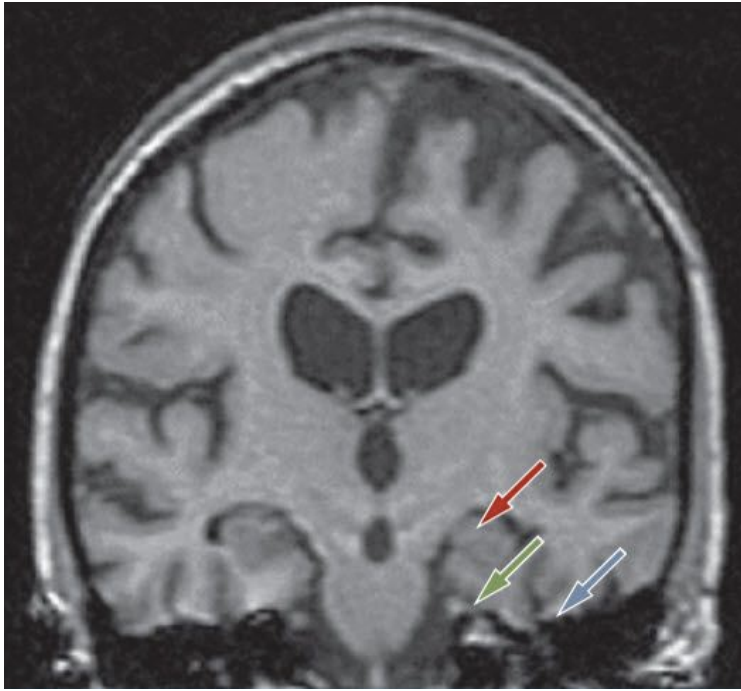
T1-weighted MRI scan of a patient with AD. Generalized brain atrophy and loss of gray matter affecting the hippocampus (red arrow), entorhinal cortex (green arrow) and perirhinal cortex (blue arrow). Abbreviation: AD, Alzheimer disease.
